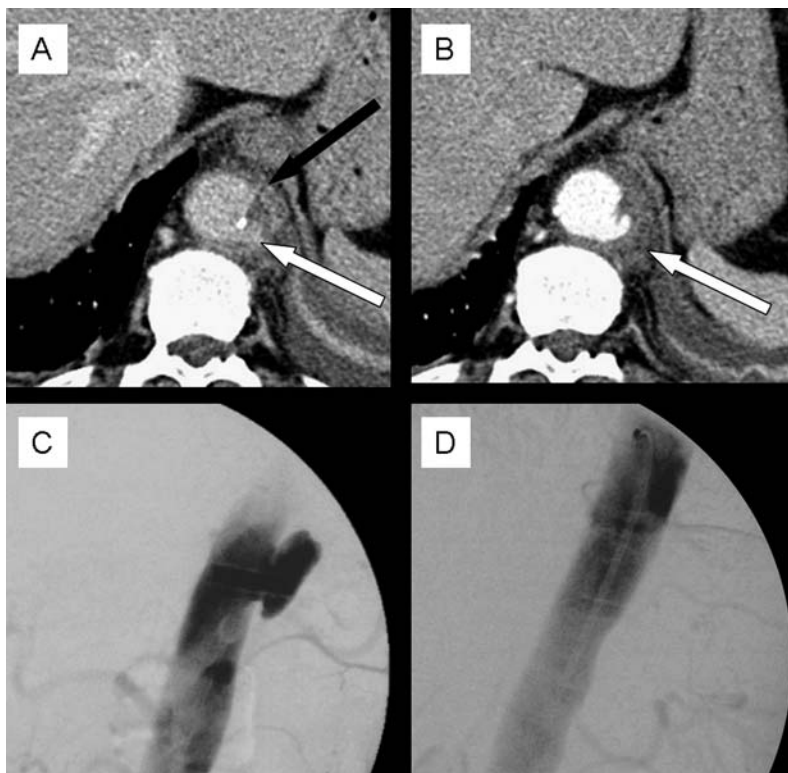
Images of the same patient as in Figure 6.6. A: CT image, transverse plane. White arrows: ulcer. Black arrow: calcification adjacent to the ulceration. B: CT image, transverse plane postcontrast. C: Angiography. D: Angiography after implantation of an endoprosthesis. C and D courtesy of H. Schumacher, MD, University of Heidelberg, Department of Vascular Surgery.
